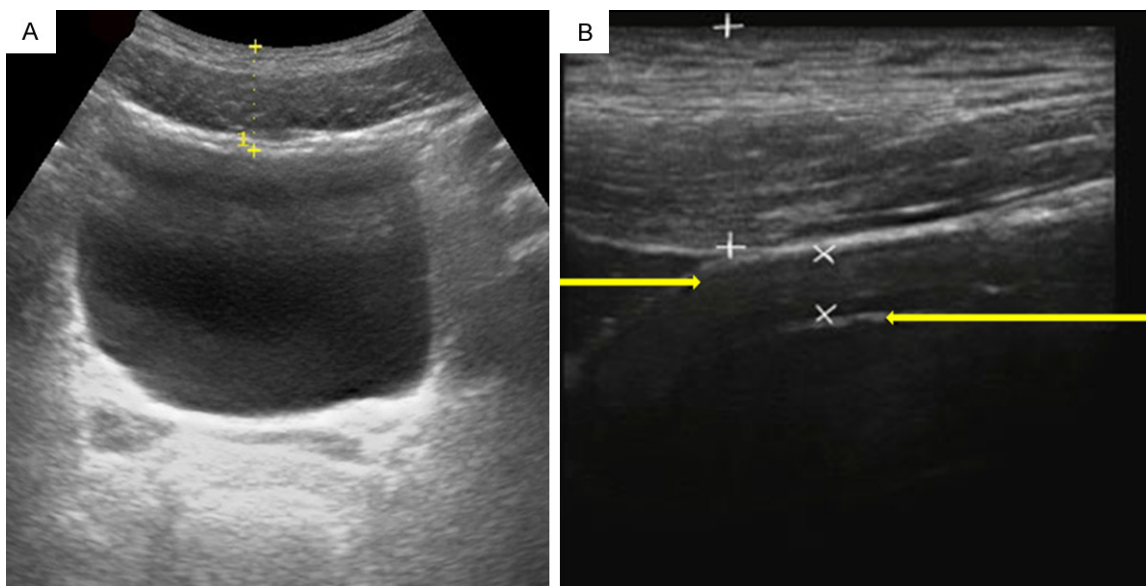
A: Distance determination between bladder wall and abdominal wall. The low-frequency ultrasound probe was used to detect the distance between the bladder wall and abdominal wall, i.e., the distance between two "+". B: DWT determination. The high-frequency linear array probe was used to measure DWT, namely the hypoechoic area (black band) between two "+" was the abdominal wall, the low signal area between the two "X" was detrusor, the hyperechoic area (white band) between the two "→" was the serosa and mucosa of bladder wall.
